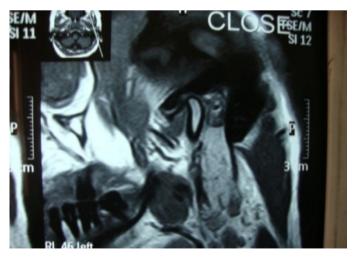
MRI for assessment of soft tissue compartment of TMJ.
